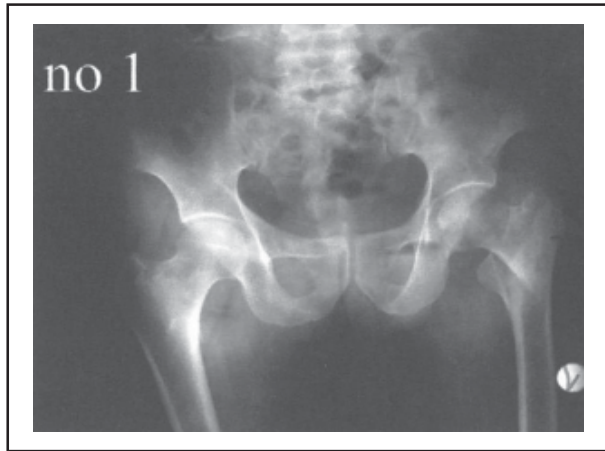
Radiography before treatment.
